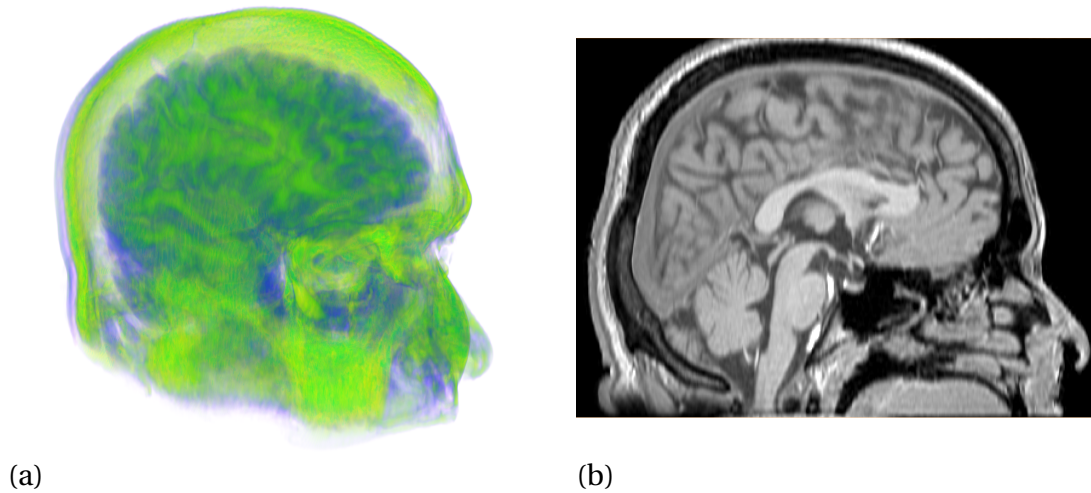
Patient-specific MRI scans of Case 1, a healthy volunteer with an open cerebral aqueduct. (a) shows the scan in three dimensions, while (b) is a single slice showing the ventricular system.
